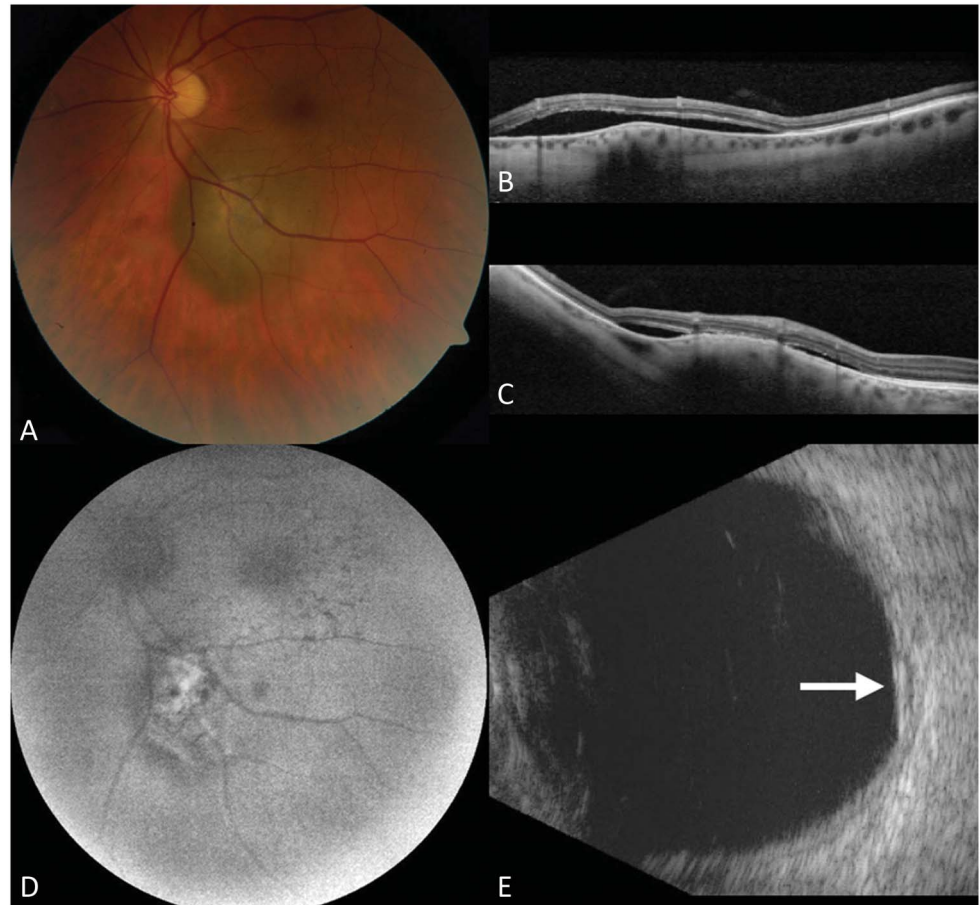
A. High-risk juxtapapillary choroidal nevus with overlying subretinal fluid, confirmed as a cap on (B) horizontal and (C) as ≤ 3 mm from lesion on vertical OCT. There was overlying orange lipofuscin, demonstrated on (D) AF. E. Ultrasonography shows a flat lesion (white arrow) of 1.6-mm thickness immediately superior to the optic nerve (yellow arrow).
